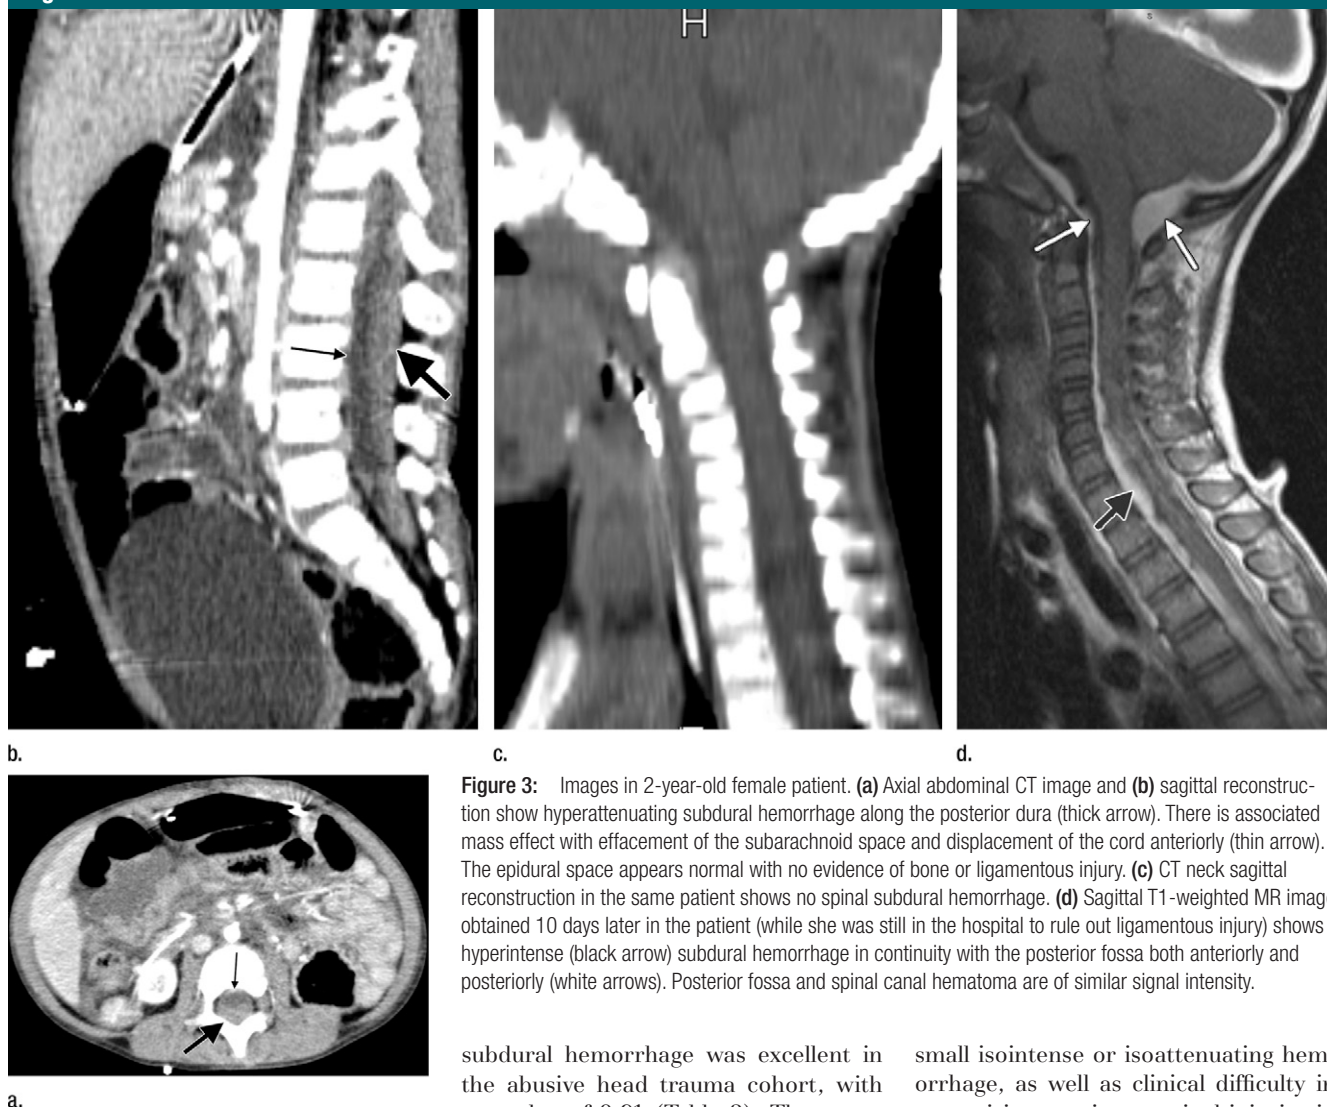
Images in 2-year-old female patient. (a) Axial abdominal CT image and (b) sagittal reconstruction show hyperattenuating subdural hemorrhage along the posterior dura (thick arrow). There is associated mass effect with effacement of the subarachnoid space and displacement of the cord anteriorly (thin arrow). The epidural space appears normal with no evidence of bone or ligamentous injury. (c) CT neck sagittal reconstruction in the same patient shows no spinal subdural hemorrhage. (d) Sagittal T1-weighted MR image obtained 10 days later in the patient (while she was still in the hospital to rule out ligamentous injury) shows hyperintense (black arrow) subdural hemorrhage in continuity with the posterior fossa both anteriorly and posteriorly (white arrows). Posterior fossa and spinal canal hematoma are of similar signal intensity.
